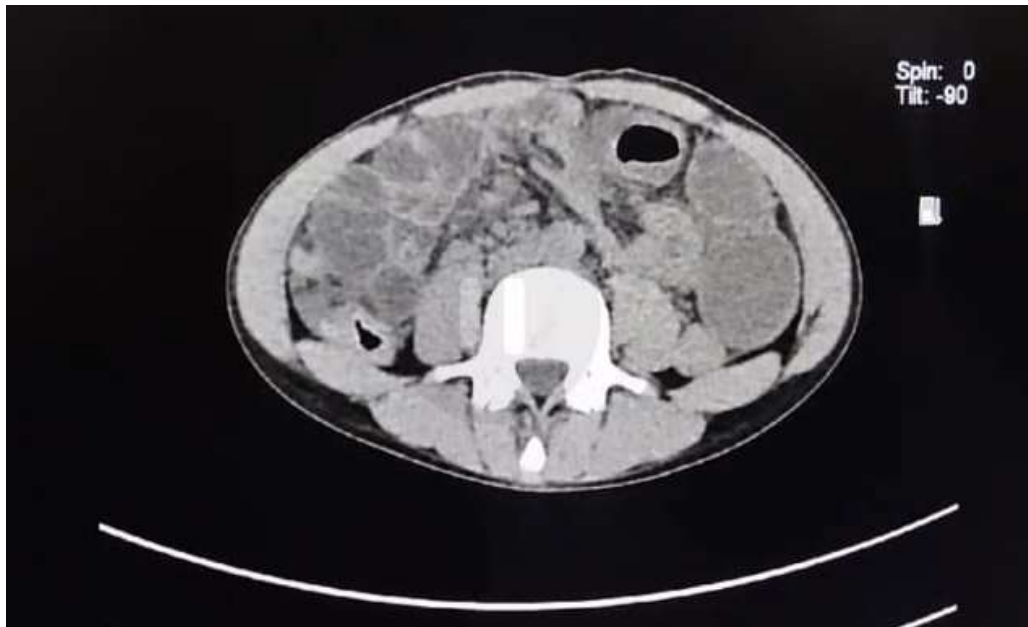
The abdominal CT scan shows distension of the small intestine, downstream from a zone of caliber disparity in the terminal ileum.
